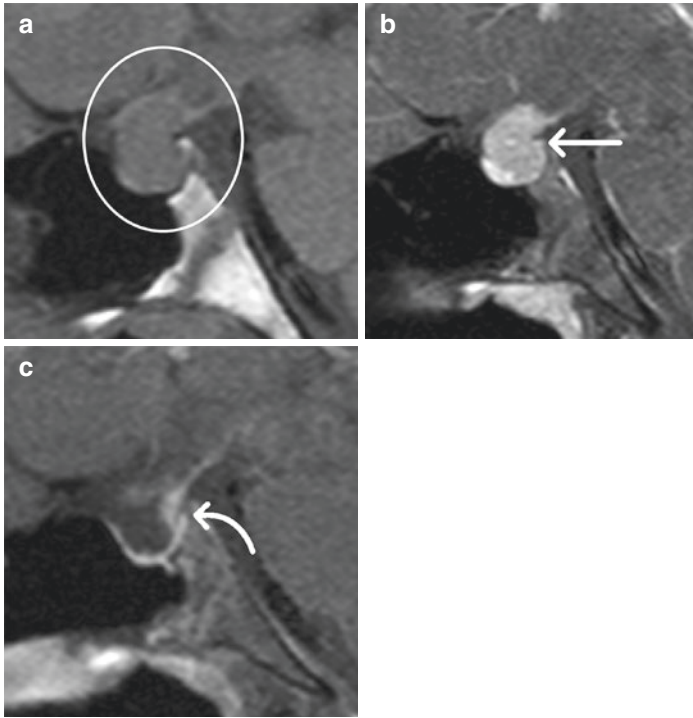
Suprasellar germinoma (SG) MRI images of a 12-year-old boy with SG presenting with new-onset diabetes insipidus and panhypopituitarism. (a) Unenhanced T1 sagittal image showing absence of the normal posterior pituitary bright spot and thickened pituitary stalk. (b) Postcontrast sagittal T1 with fat saturation demonstrate thickened enhancing pituitary stalk (straight white arrow) MRI image two years following treatment. (c) Postcontrast sagittal T1 with fat saturation demonstrates resolution of the previously noted pituitary stalk thickening (curved arrow)
